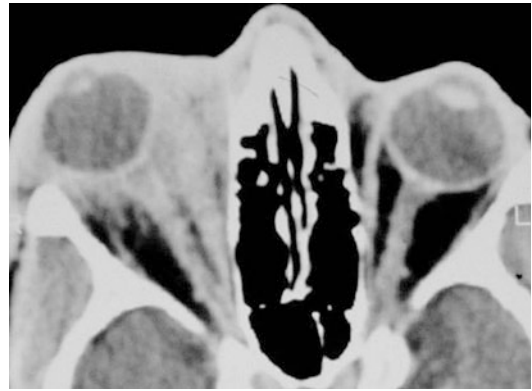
Axial CT of the orbits, showing subacute right orbital inflammation, manifests as ill-defined opacification of the peribulbar fat, some “cuffing” of the anterior part of the optic nerve and “streaked” opacities within the retrobulbar orbital fat
